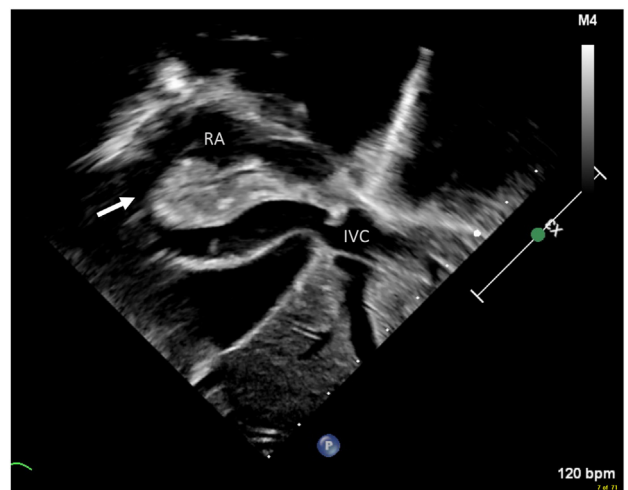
Two-dimensional transthoracic echocardiogram subcostal sagittal midsystolic view demonstrates a large echobright mass (arrow) attached to wall of the IVC and protruding into the RA.
